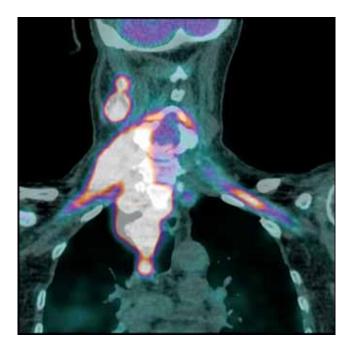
PET/CT scan showing increased activity in the lymph node masses of the neck and mediastinum on the right side and the brachial plexus in the left subclavian region.
